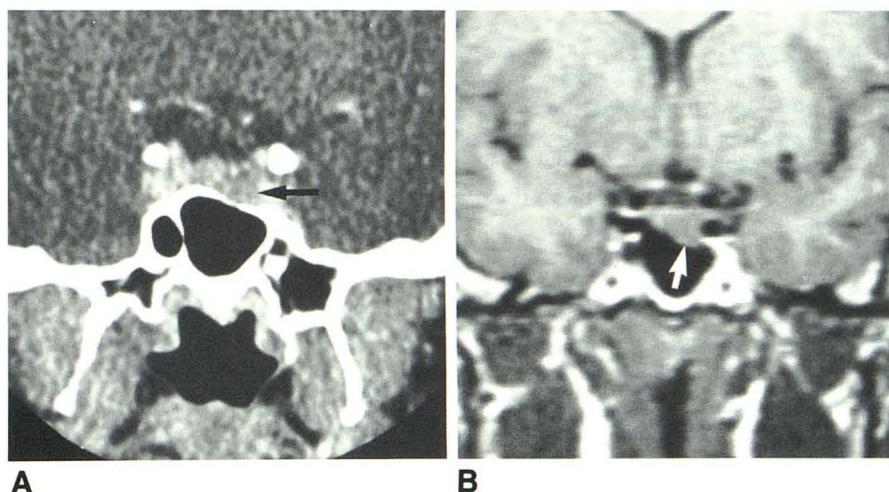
Verified microadenoma more effectively shown by CT than MR. A, CT scan reveals focal low-density mass (arrow) associated with thinning and sloping of sellar floor. B, Short TR image shows sloping of the sellar floor (arrow), but pituitary gland has normal homogeneous signal intensity.
